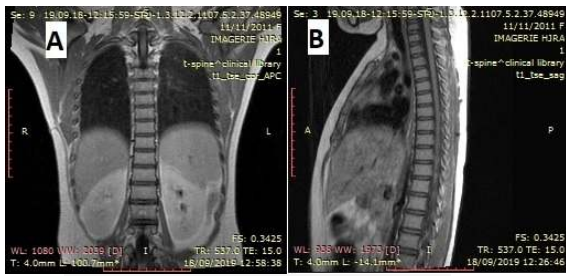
Image from post-treatment MRI.
